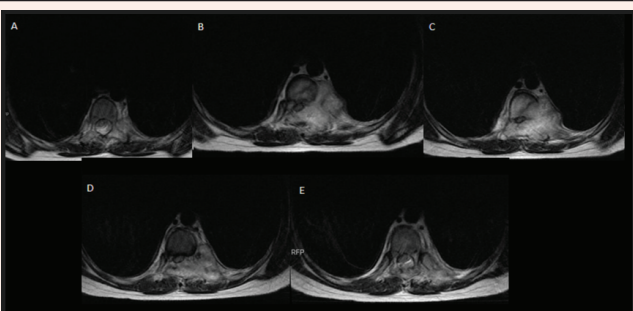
Magnetic resonance imaging of the thoracic spine in T2 in axial craniocaudal sections at the level of the T7 vertebra (A), T7-T8 intervertebral disc (B), T8 vertebra (C), T8-T9 intervertebral disc (D) and T9 vertebra (E), showing an expansive lesion affecting the spinal canal, further to the left, with severe stenosis at these levels.
